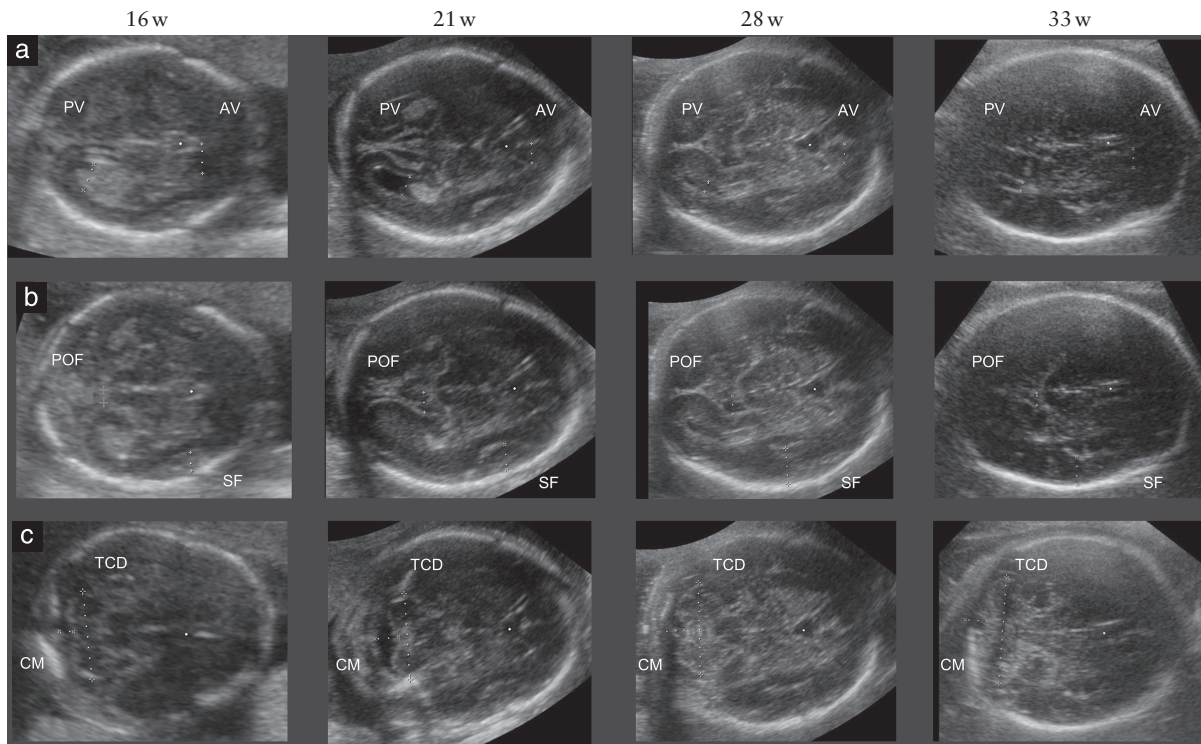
Reconstructed ultrasound planes showing caliper placement for fetal brain structure acquisition at different gestational ages for transventricular plane (a), transthalamic plane (b) and transcerebellar plane (c). AV, anterior horn of lateral ventricle; CM, cisterna magna; POF, parieto-occipital fissure; PV, atrium of posterior horn of lateral ventricle; SF, Sylvian fissure; TCD, transcerebellar diameter; w, completed weeks' gestation.
